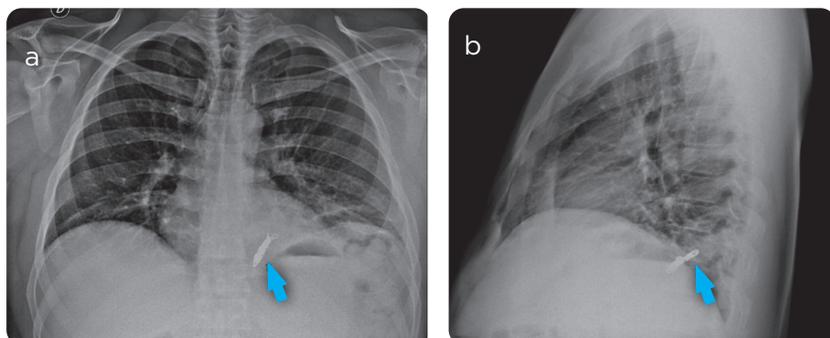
Chest X-ray with PA and lateral view showing embolization material in the left lung base, without significant alterations in lung fields.
